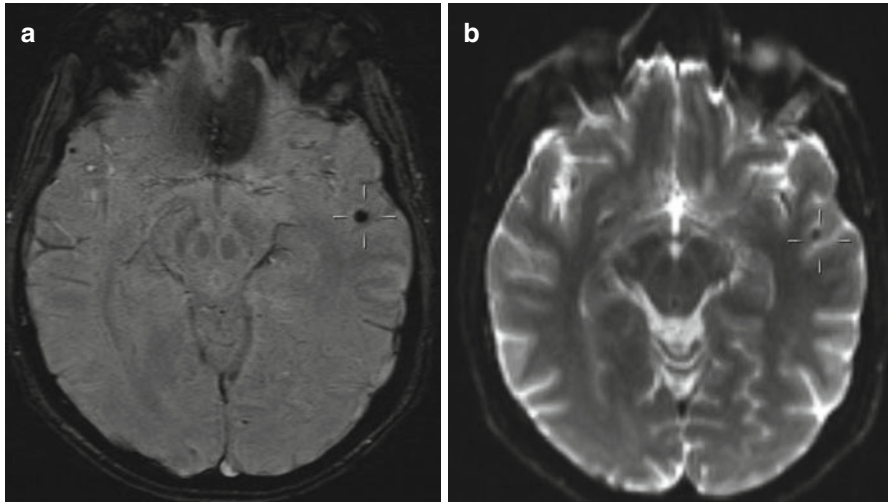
(a, b) Microbleed in a patient with hypertension. SWI scan shows a hypointense focus of the microbleed in the left temporal lobe (a), which is less visible on the T2-weighted MR image (b)
